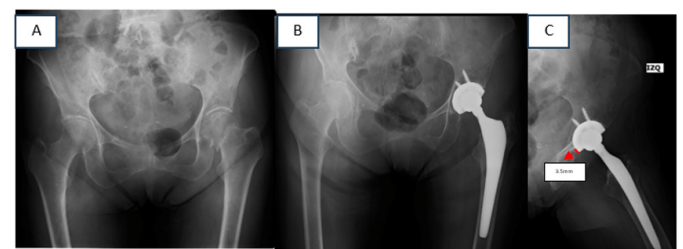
Preoperative radiograph of the patient on admission to the emergency department (A). Postoperative radiographs the day after surgery: AP (B) and lateral with lateral protrusion of the acetabular cup <3mm (C).
